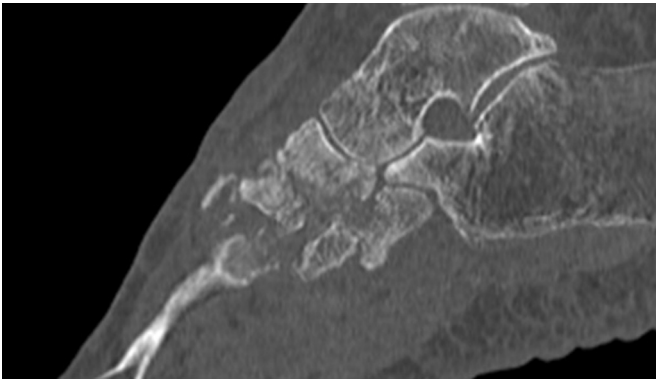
CT scan of the right foot showing a lytic lesion of the navicular bone and the metatarsals.
